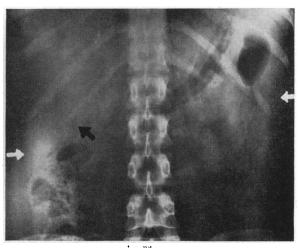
Obscuration of the liver edge caused by acute inflammation of the hepatoduodenal ligament. The patient had constant, cramping and nonradiating epigastric pain of 24 hours duration. Moderate guarding in the right upper quadrant of the abdomen was noted. No masses were palpable. The temperature was not above normal range. Leukocytes numbered 14,700 per cu. mm.—80 per cent segmented forms. On the plain film of the abdomen the line of diminished density which defined the lower border of the liver was obscured (black arrows). The layer of pericolic fat believed to cause this line was obscured by the inflammatory edema. In contrast the lateral border of the liver and the inferior border of the spleen were sharply defined (white arrows).
